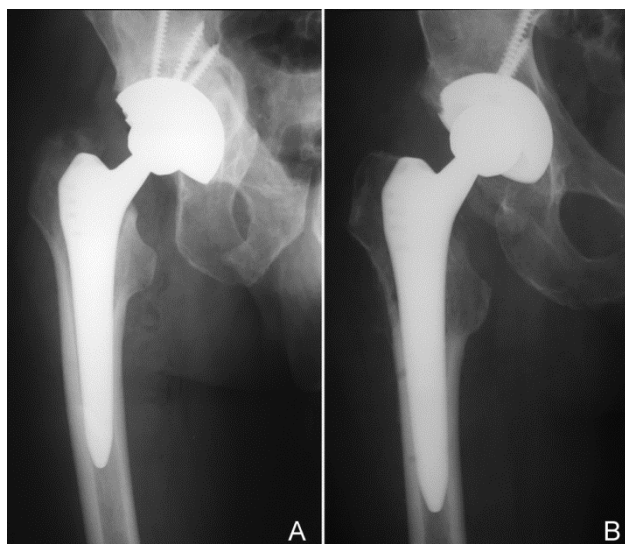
Radiographs of the right hip joint after THA with the ZIMMER implant and cementless fixation of both components. X-rays: A – patient 1; B –patient 2
